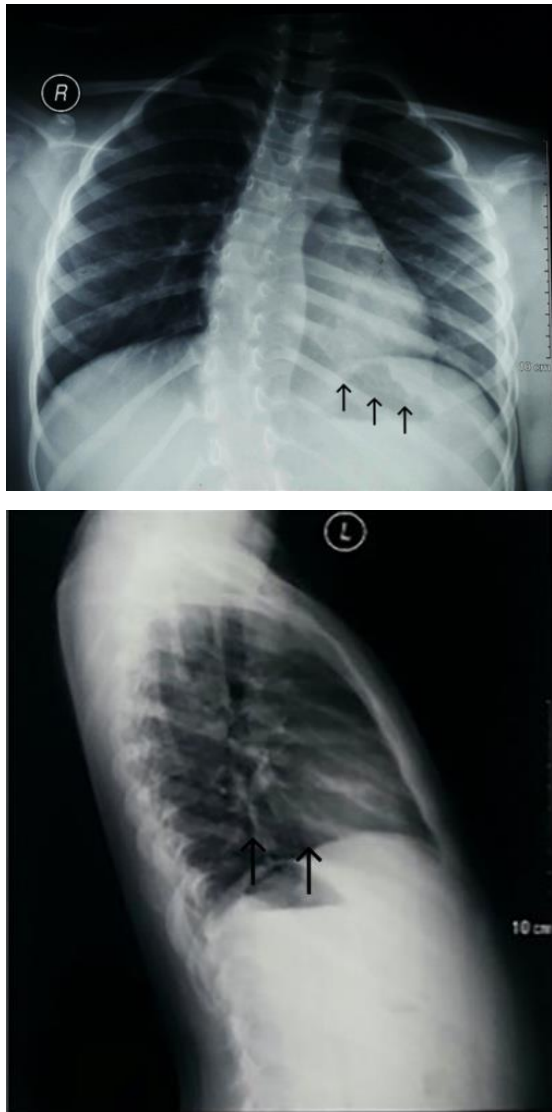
Plain thorax radiography showed a lytic ballooning lesion on the 9th left rib.
